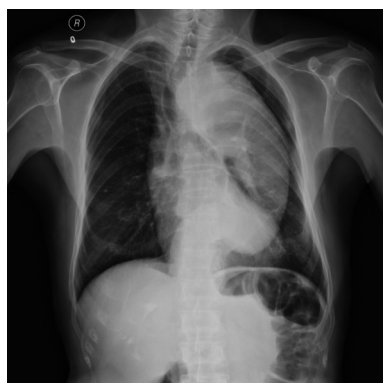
Chest radiography confirmed concomitant aneurysm and tracheal compression.
